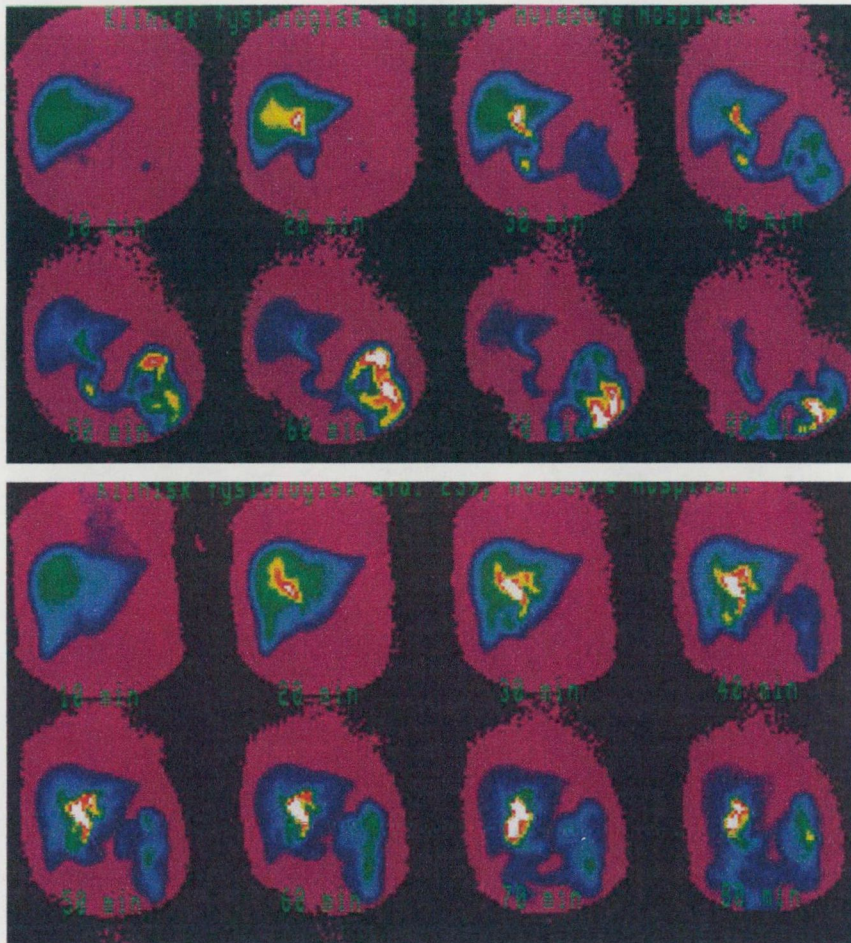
The upper panel depicts a static hepatobiliary scintigram of a control patient with normal bile flow, and the lower panel that of a patient with SOD and accumulation of the isotope in the biliary tree.
